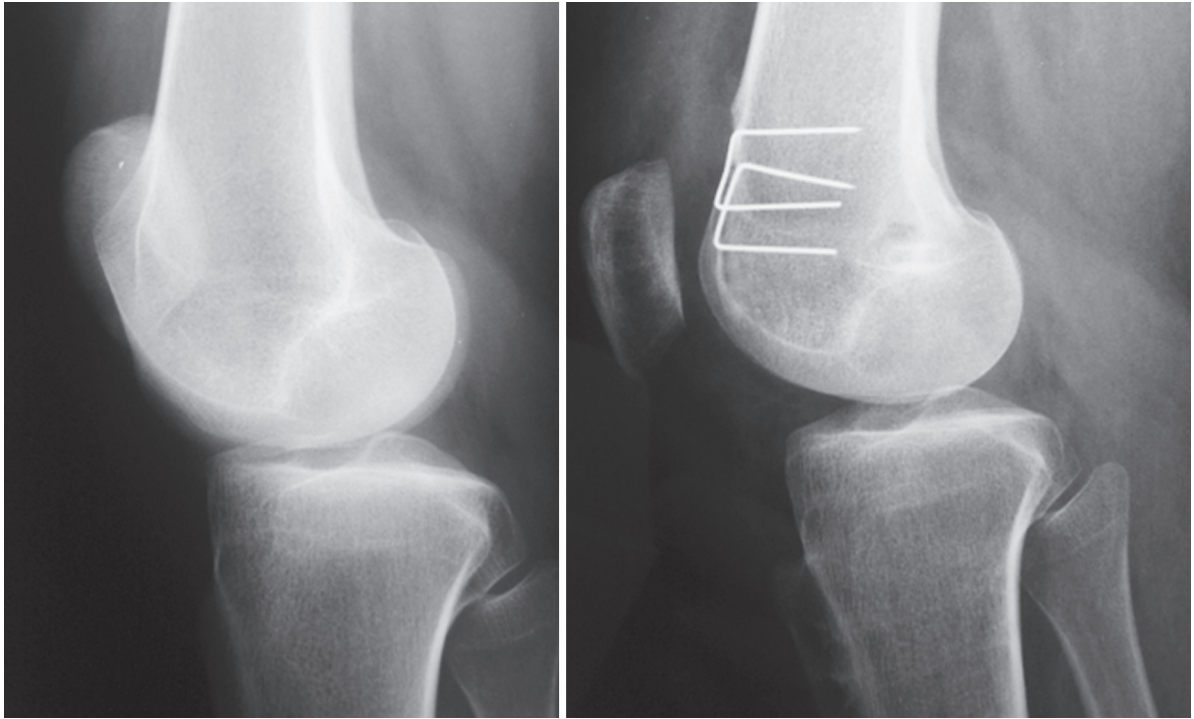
Pre- and postoperative lateral x-rays showing the resection of the supratrochlear bump and trochlear prominence correction. Additionally, patellar tilt is clearly improved
